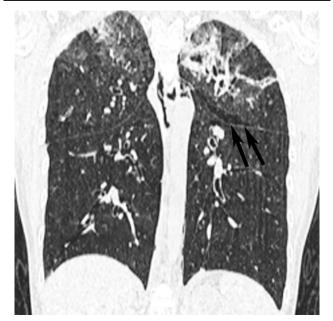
PIE (subpleural type) on CT (MPR-coronal) in a 17-year-old female patient with acute myelogenous leukemia with a history of allo-HSCT, and with a conservative treatment duration of 33 days. PIE—banded air in subpleural in the left upper lobe (black arrow). With cGVHD-related IPS in the upper lobe. CT=computed tomography, PIE=pulmonary interstitial emphysema. cGVHD = chronic graft-versus-host disease, IPS = interstitial pulmonary syndrome.
